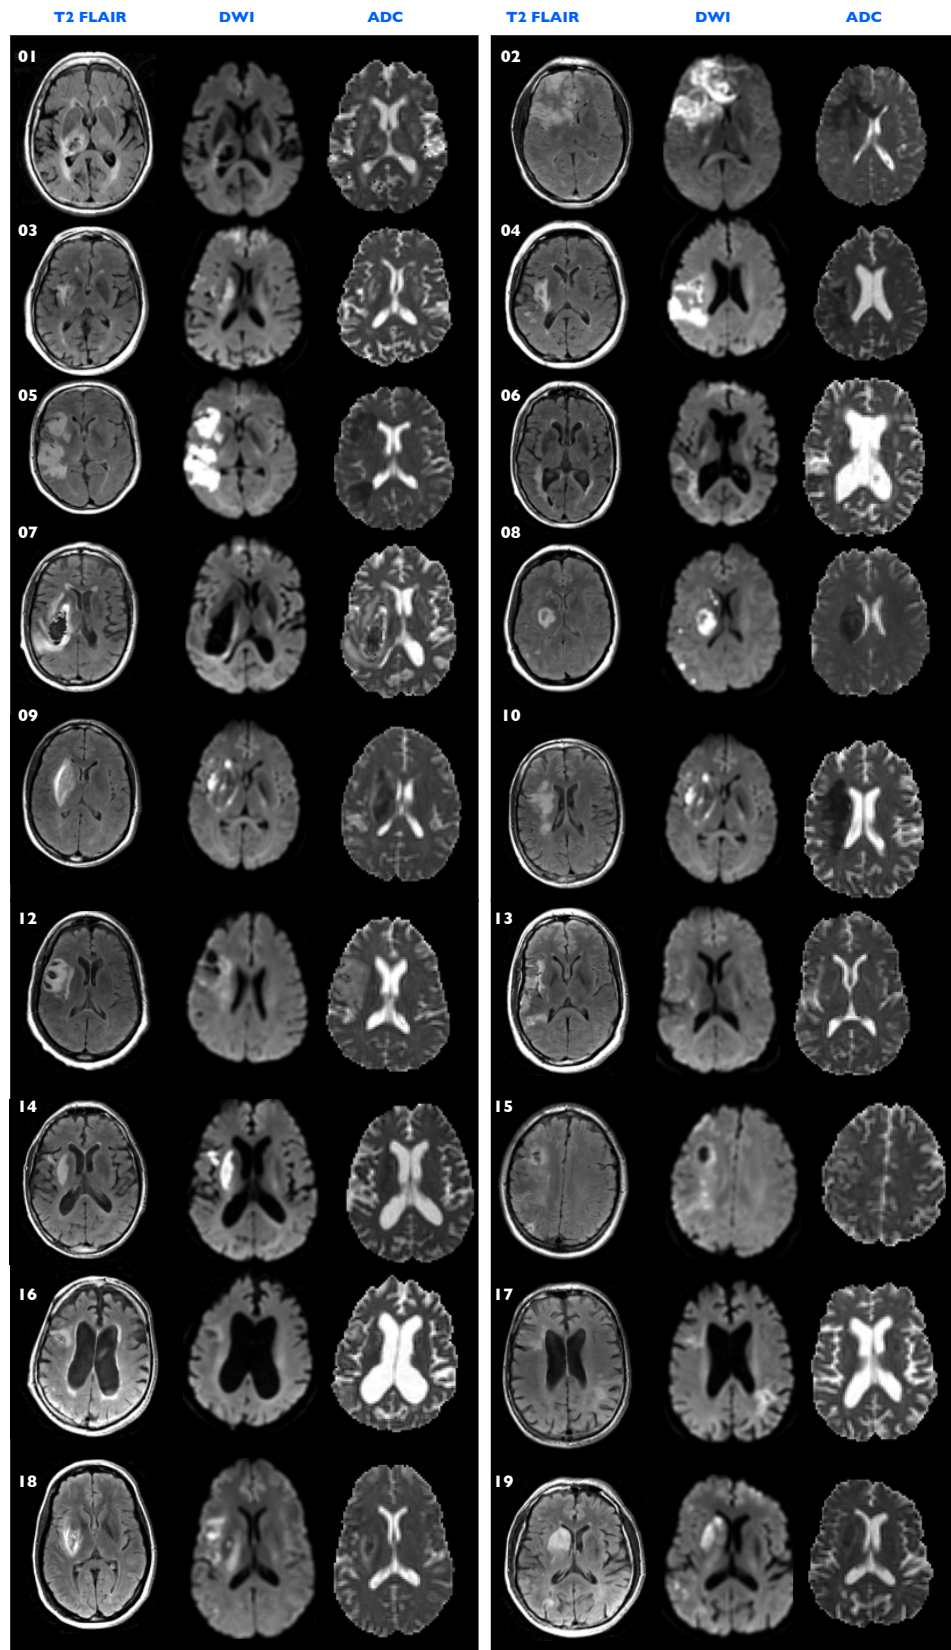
Native, acute stage MRI contrasts of individual subjects (n=18)
